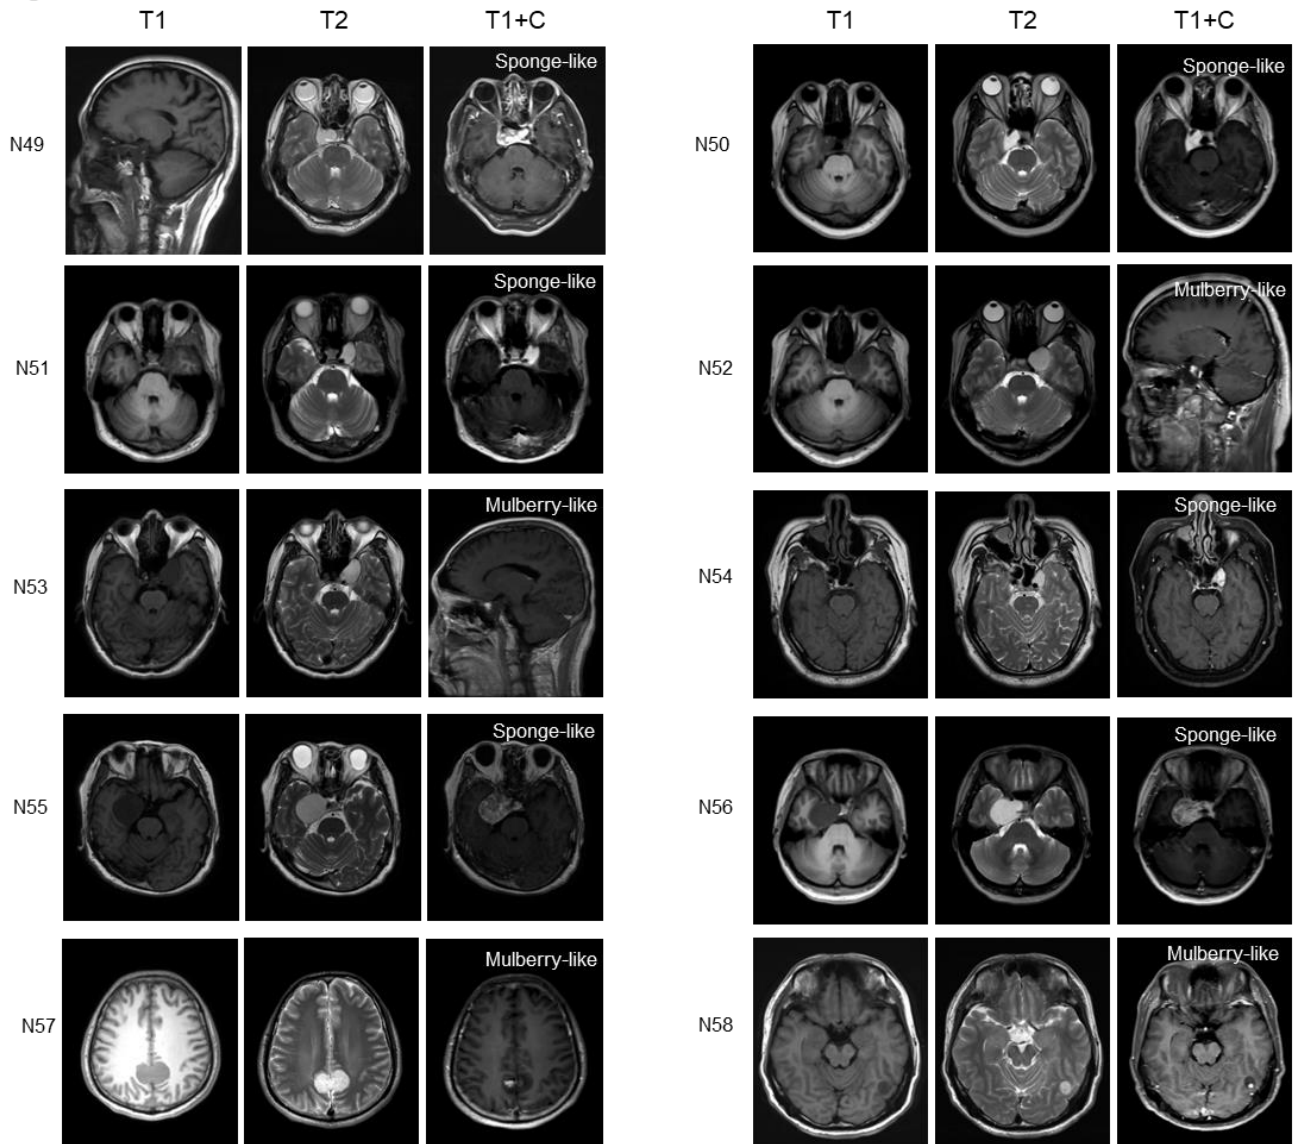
The MRI of 58 individuals in this study. 58 patients were categorized into sponge-like or mulberry-like according to the imaging appearance of contrast-enhanced T1-weighted (T1+C) imaging. Numbering of individuals was given at the left.
